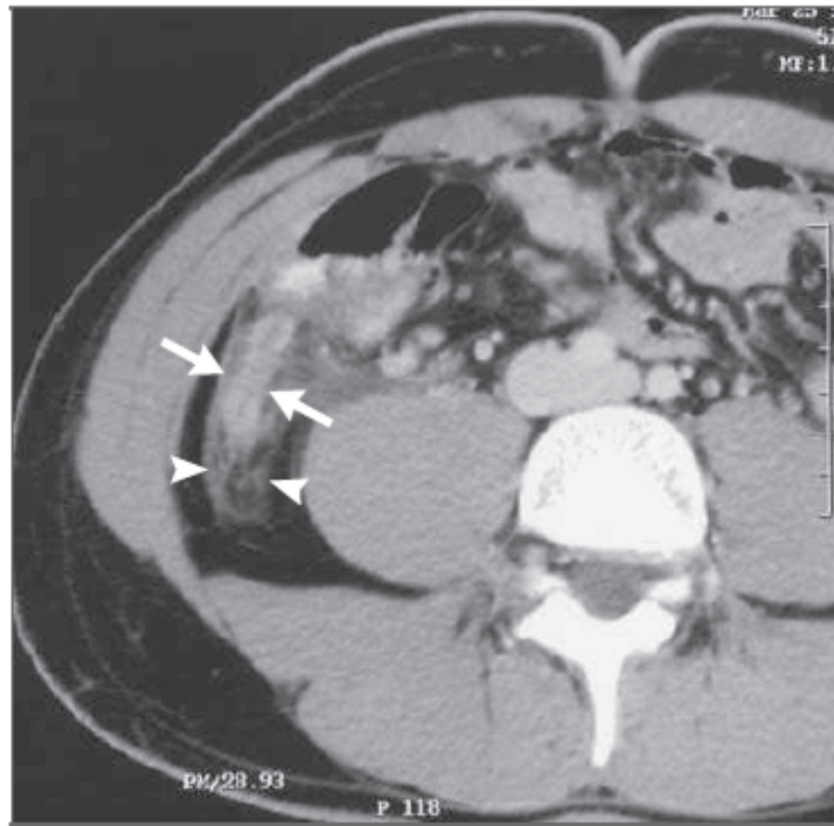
CT Scan in an 18-Year-Old Man with Abdominal Pain and Nausea.
